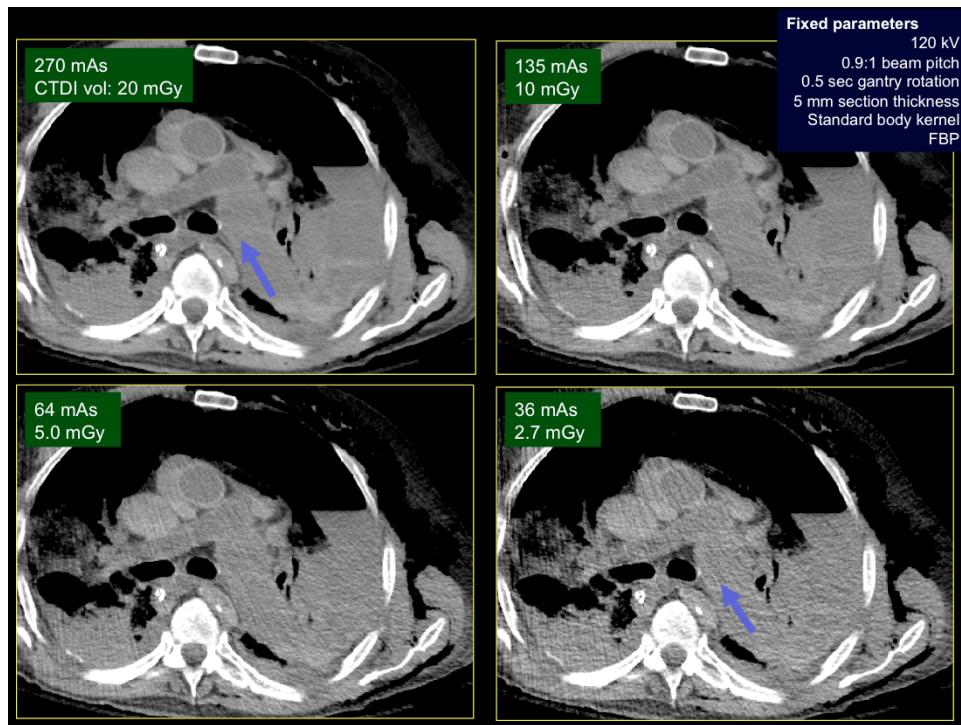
Post mortem chest CT of a 70 year old male (72 kg) with known diagnosis of left pulmonary artery angiosarcoma at various tube currents. Low dose images acquired at 36 mAs (CTDIvol: 2.7 mGy) have higher image noise, however shows the enlarged left main pulmonary artery (arrows), subcutaneous emphysema and left hydropneumothorax. Acceptability of low dose images would have certainly improved with administration of intravenous contrast and lower kV.
